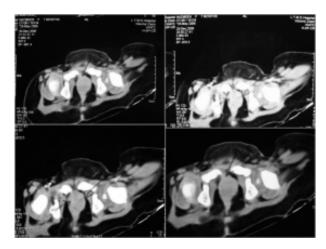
CT scan showing a 1.2 X 1.5 cms tumour arising from posterior wall of vagina.
